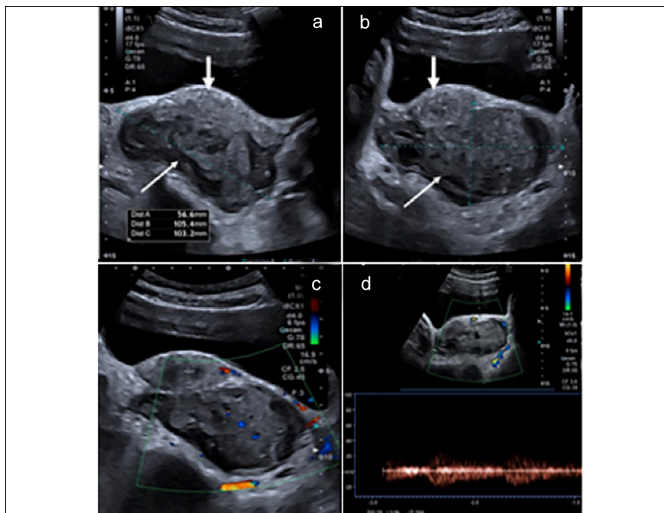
(a) Longitudinal and (b) Transverse ultrasound images show a heterogeneous echogenic mass (long white arrow) posterior to the uterus which is displaced anteriorly and to the right of midline (short thick arrow). (c) Colour Doppler and (d) Spectral Doppler ultrasound image show presence of vascularity within the lesion.
